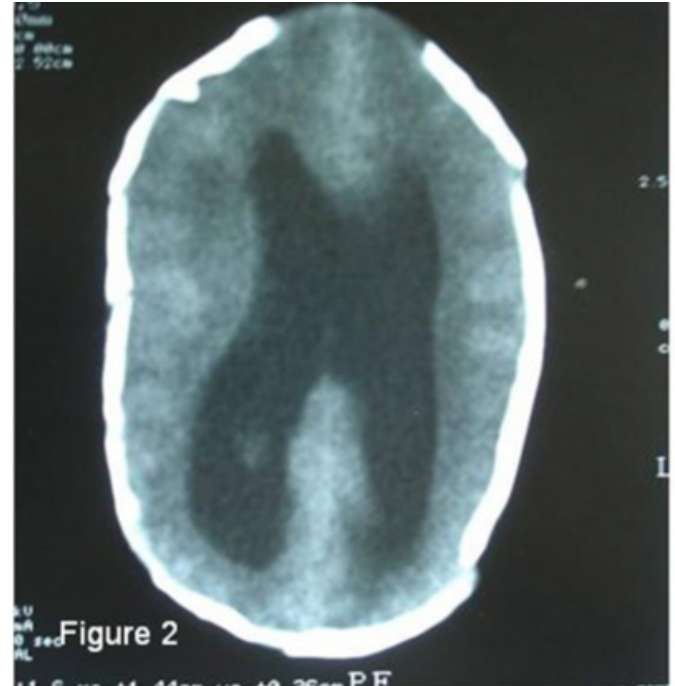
CT scan shows ventriculomegaly and EDH located in the right parietal region.
